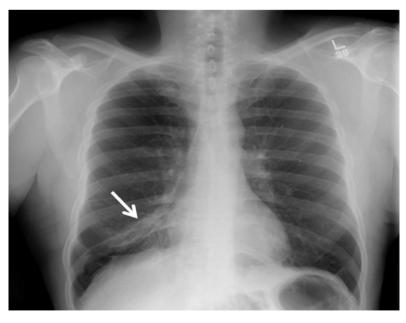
Frontal chest x-ray shows increased lung volumes and ill-defined opacity in the right infrahilar region consistent with middle lobe segmental atelectasis (arrow) [18]
